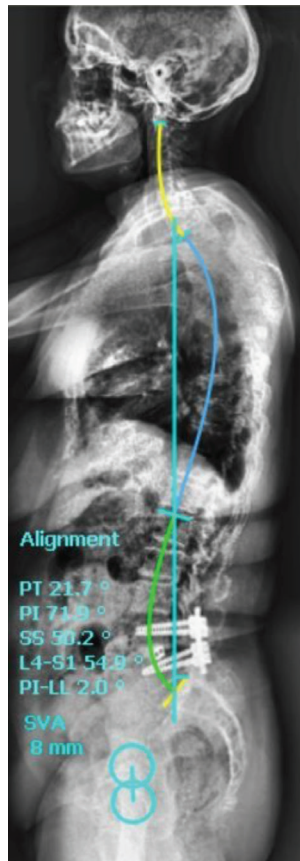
Postoperative lateral spine radiograph of patients treated with short level fusion surgery
